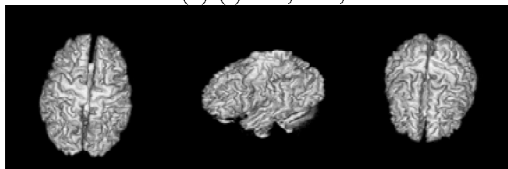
3D rendering of the white matter(top) and gray matter(bottom) of a real T1-weighted real MR image data.
